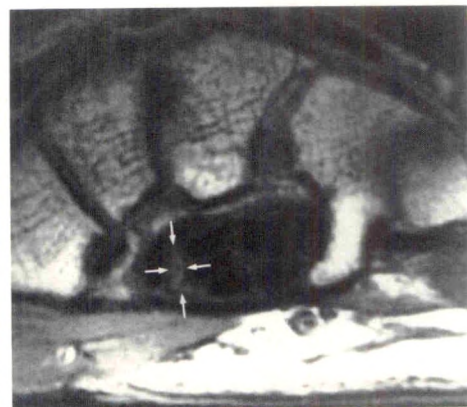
Interposition of median nerve. Axial MR image (TR 600, TE 25) in normal volunteer. Left wrist viewed toward elbow with palm down. Note that long axis of median nerve (arrows) is perpendicular to flexor retinaculum at this level and that median nerve has migrated deeper into carpal tunnel between flexor pollicis longus and superficial and deep flexors of fingers.
